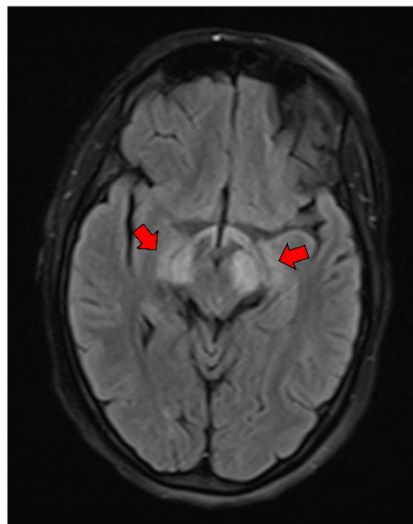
Cerebral Peduncle lesions on FLAIR sequence in axial plane
